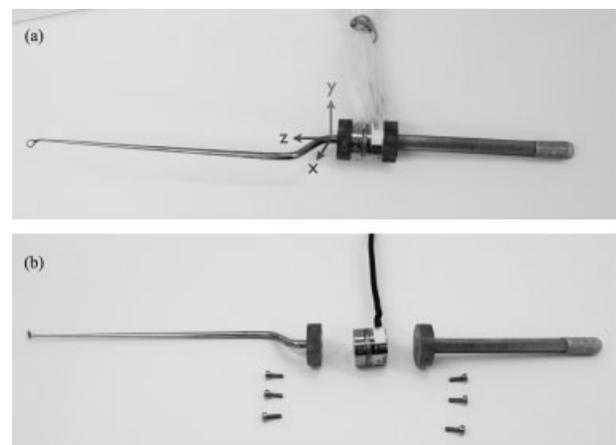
The modified Hardy ringed pituitary curette is shown above. (a) The tool components disassembled, demonstrating the tip and handle attached to the Ultem disks, the Nano-17 force sensor, and the screws for assembly. The forces were measured using the coordinate frame shown here. (b) The tool assembled with force sensor sheathed in ultrasound probe bag for a sterile in vivo experiment.
